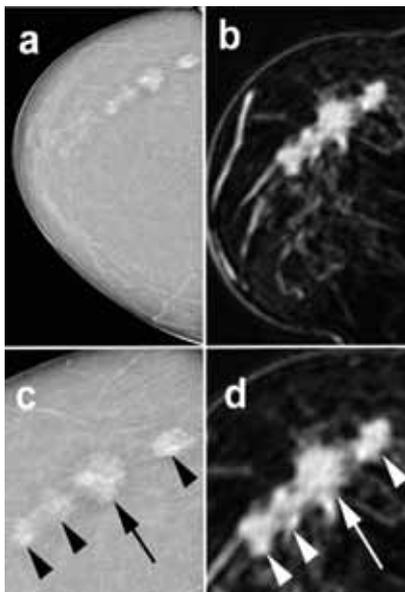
The sensitivity of Contrast-Enhanced Dual Energy Mammography (CEDEM) has been shown to be equivalent to that of breast MRI. Images a & c: CEDEM; images b & d: MRI.
